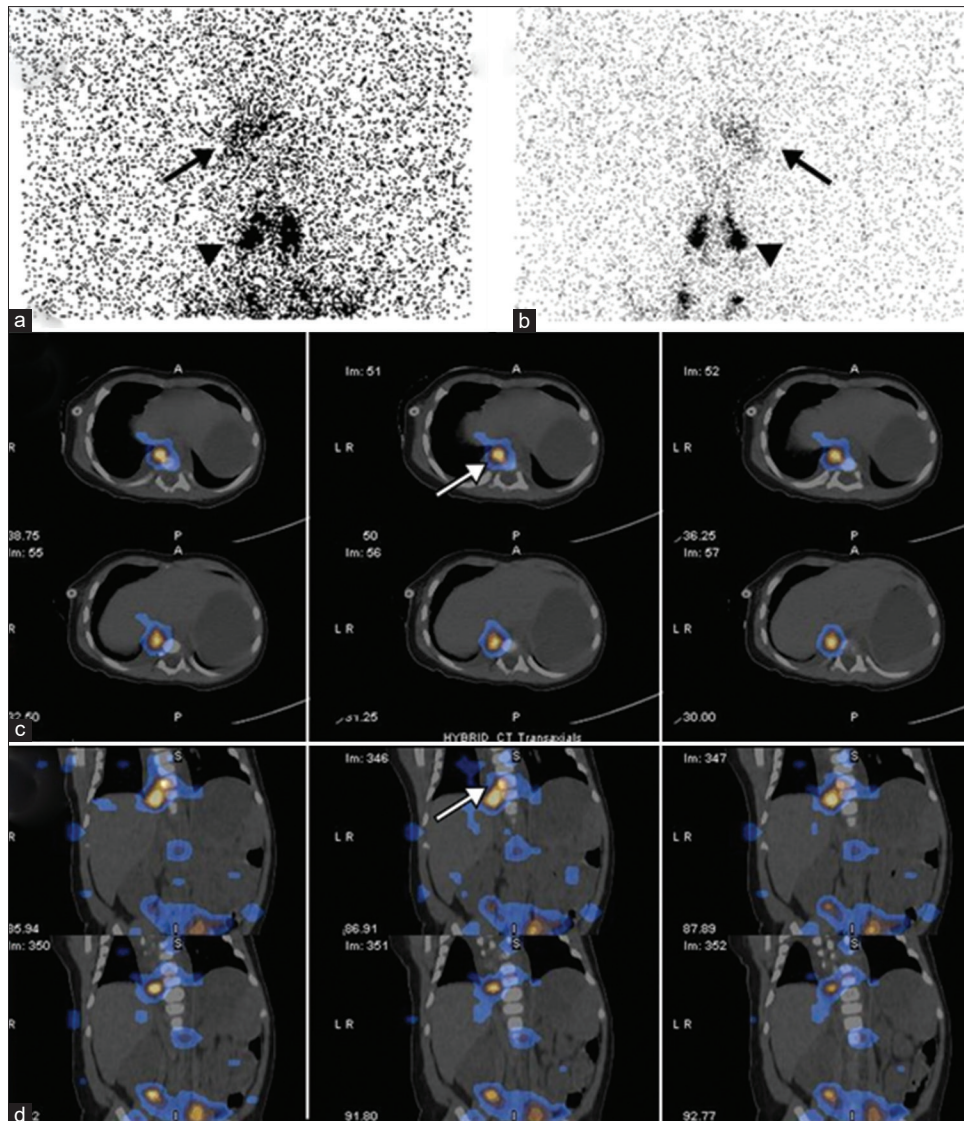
^{99m}Tc -S colloid LSG images. (a) Anterior and (b) posterior whole-body planar images acquired immediately after tracer injection reveal physiological tracer accumulation in the inguinal lymph nodes (black arrowhead) and liver (black arrow) did not reveal any foci of abnormal tracer localization within the thoracic cavity or elsewhere. (c) Axial and (d) coronal sections of SPECT/CT identified the site of leak in the thoracic duct that corresponds to D8 vertebral level (white arrow). SPECT/CT: Single-photon emission computed tomography/computed tomography
